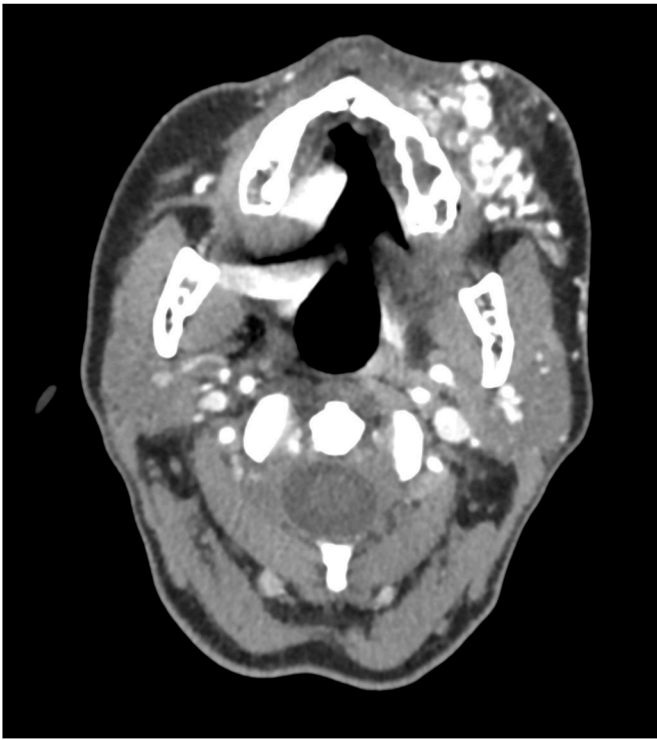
Patient 1: Contrast Enhanced CT. Axial Scan. Typical aspects of an AVM are evident with a plethora of increased-size vessels running in the left cheek.
